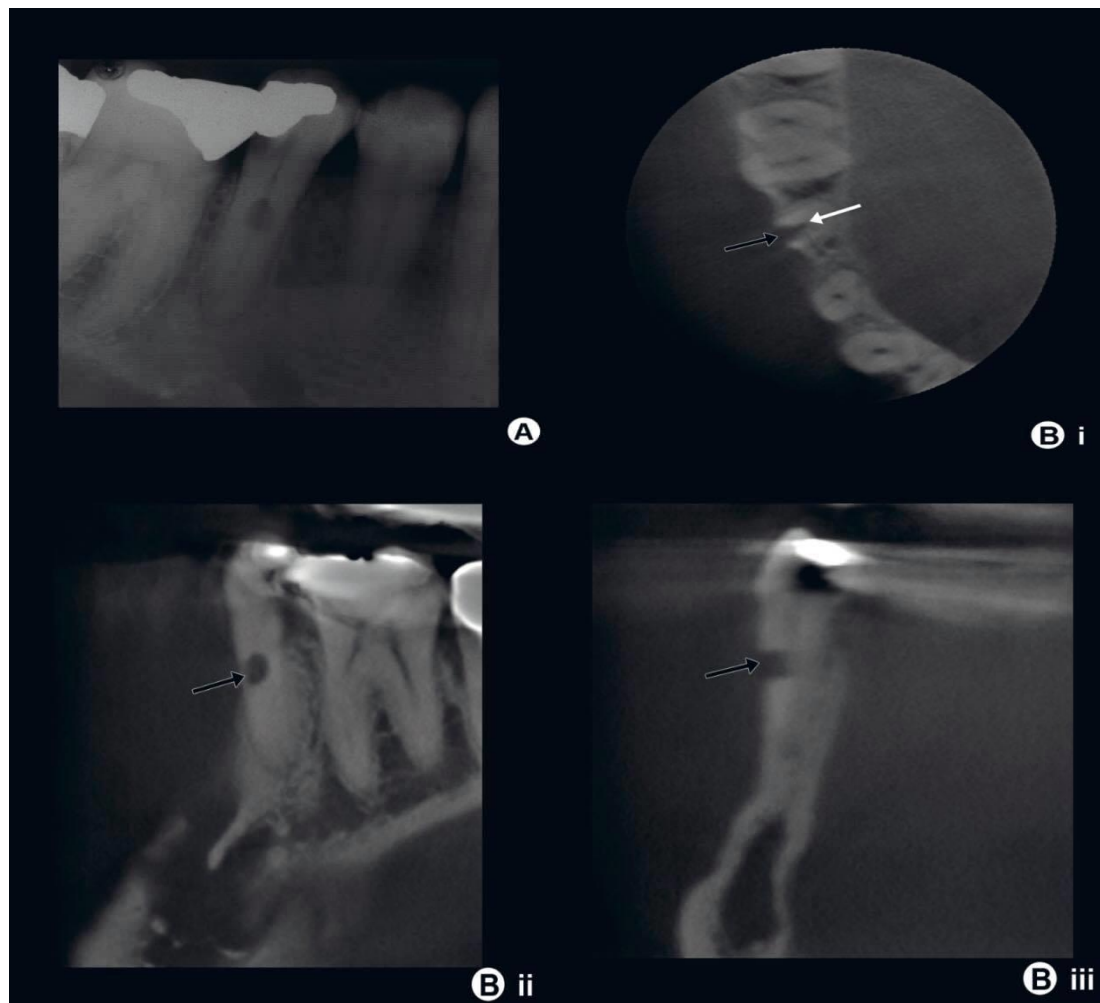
(a) Periapical radiograph of a mandibular second premolar tooth, which appears to be affected by root resorption. It is unclear from the radiograph whether the root resorption is internal or external or if the resorptive process has perforated the root canal wall. (b) Axial (i), coronal (ii) and sagittal (iii) CBCT slices through the tooth in the area of interest. It is clear from the CBCT images that the resorption originated on the external surface of the root (black arrows) and has perforated the root canal wall. The root canal shows no signs of ballooning enlargement associated with internal resorption (white arrow).
